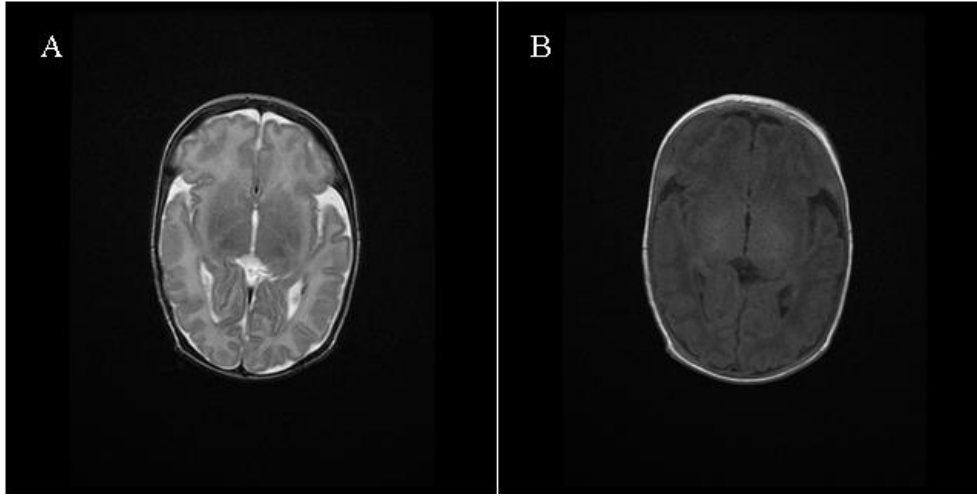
Images from two different sequences of the same patient; Image A is a T2-weighted MR image; Image B is a T1-weighted MR image.
